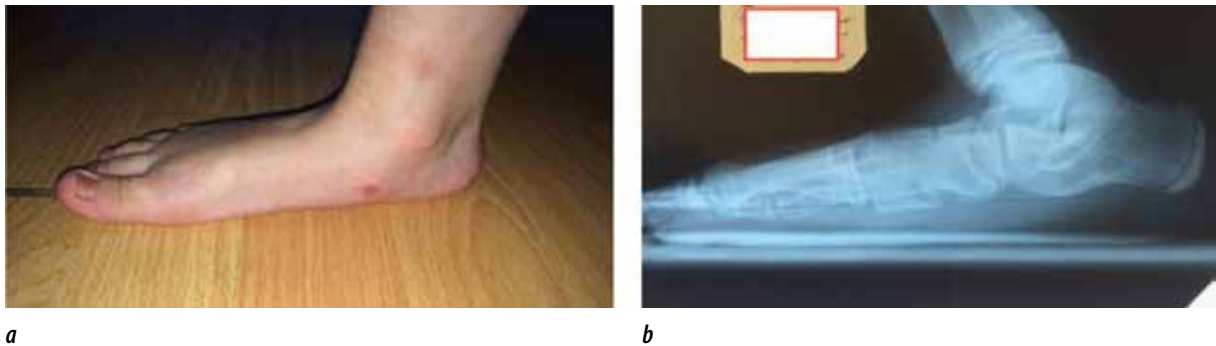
General appearance of foot (a) and patient X-ray examination (b) before treatment
